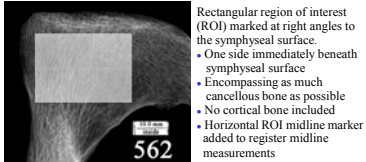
ROI defined in plain film radiograph
